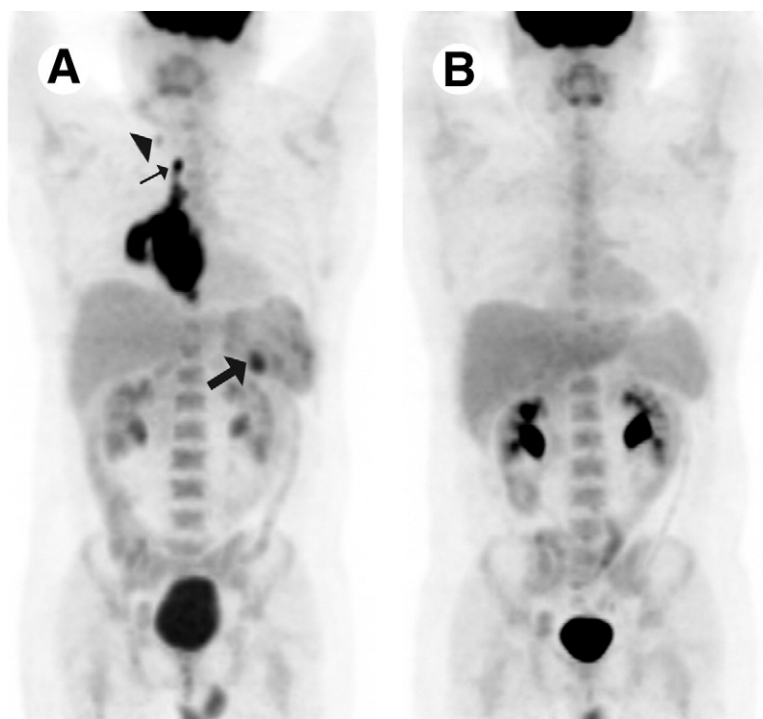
Evaluation of Response to Therapy on Maximum Intensity Projection (MIP) FDG PET images. On the pretreatment image for Hodgkin's lymphoma (A) intense abnormal FDG tracer activity is clearly present in the right hilum and mediastinum. Focal tracer activity in a high right paratracheal lymph node is clearly well above mediastinal or liver background tracer activity (thin arrow), and foci of tracer activity in the spleen are also above liver tracer background activity, consistent with splenic (below diaphragm) involvement (thick arrow). A small focus of right supraclavicular tracer activity, equivalent in intensity to mediastinal background (arrowhead), corresponds to a 6-mm lymph node, and allowing for the small node size, is considered abnormal as well. None of these abnormalities required an SUV measurement to identify. On the posttreatment images (B) there is complete resolution (a complete metabolic response) to the aforementioned abnormalities; there is no residual tracer activity above mediastinal background level.
